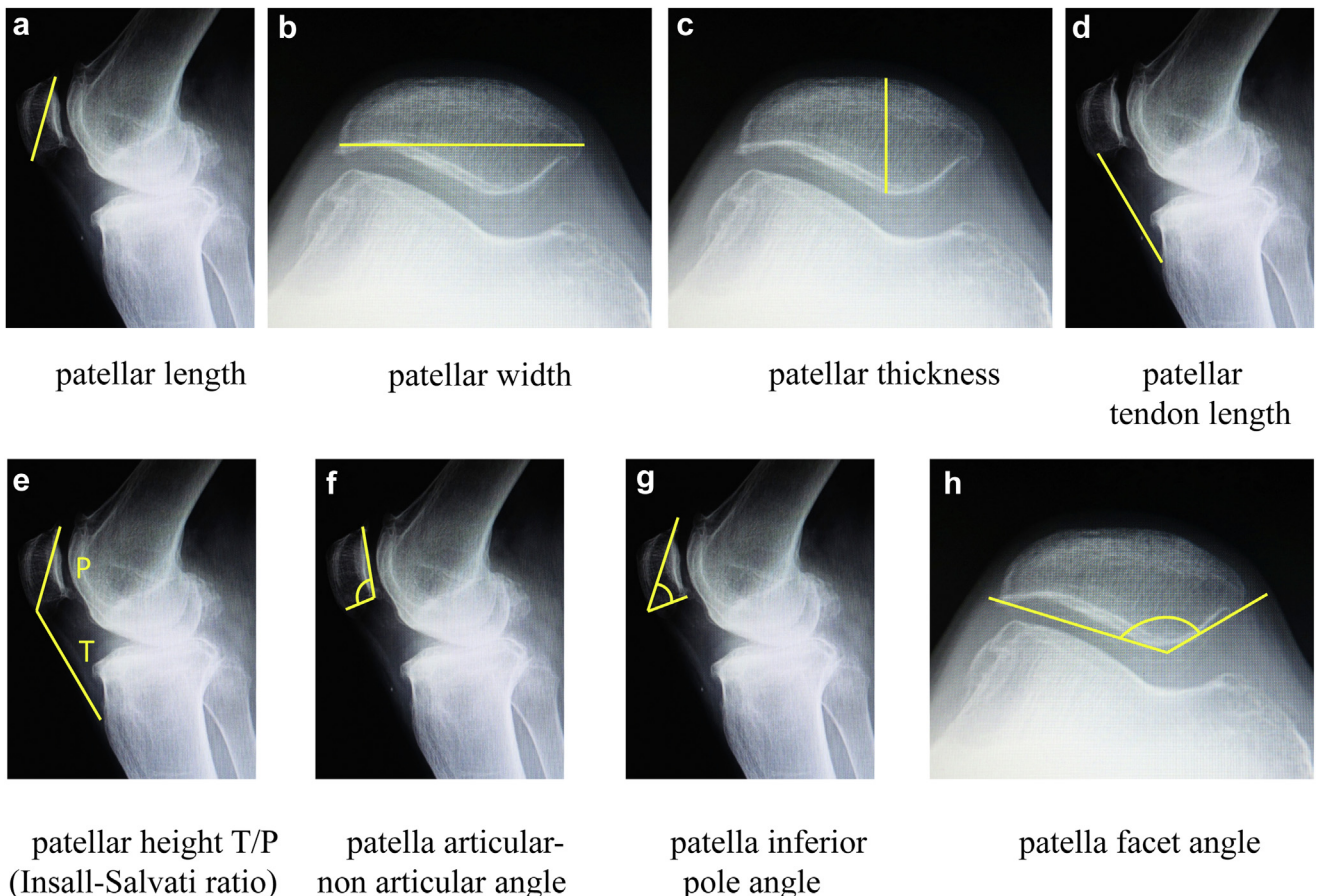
Parameters evaluated on radiographs.
